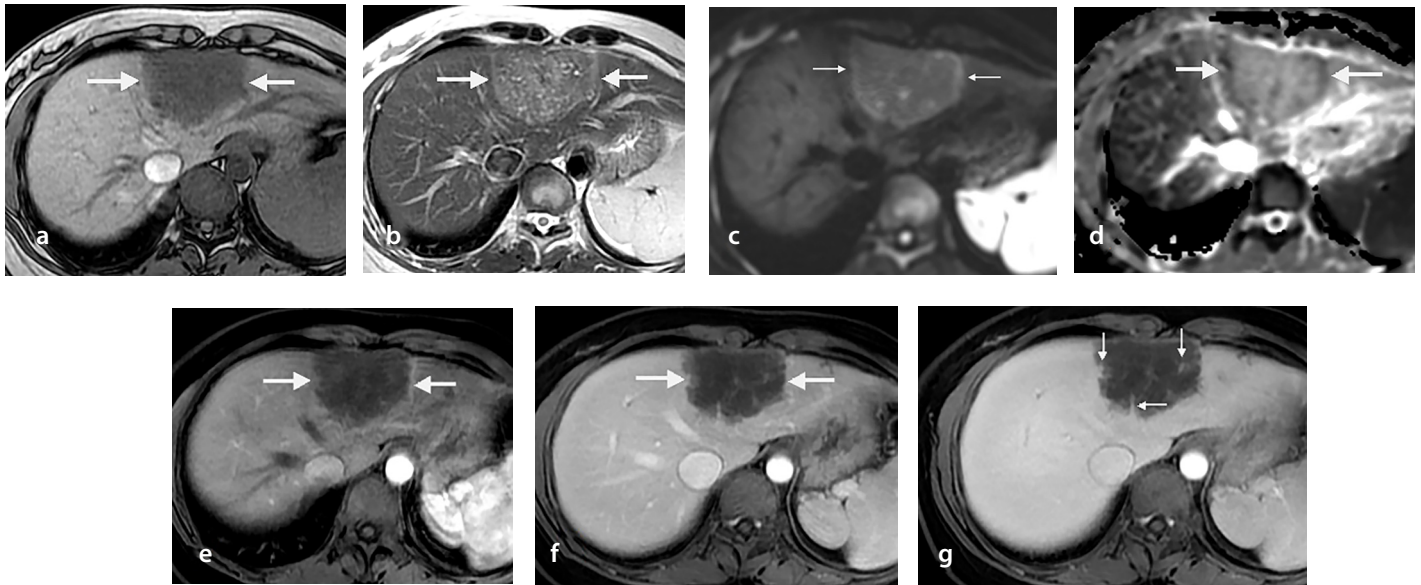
A 35-year-old woman with hepatic alveolar echinococcosis. On dynamic contrast-enhanced liver magnetic resonance imaging, a 7-cm mass-forming lesion (arrows in a–f) was observed in segments 2/4a. It appeared hypointense on T1-weighted images (a) and mildly hyperintense on T2-weighted images (b). Note the punctate hyperintense foci within the lesion on T2-weighted images, possibly corresponding to small vesicles. Diffusion-weighted imaging (c) demonstrated peripheral ring-like diffusion restriction, and the apparent diffusion coefficient map (d) revealed a hypointense rim confined to the periphery. On post-contrast arterial (e), venous (f), and hepatobiliary (g) phases, no significant contrast enhancement was noted within the lesion, except for minimal enhancement along septum-like internal structures (small arrows in g).
